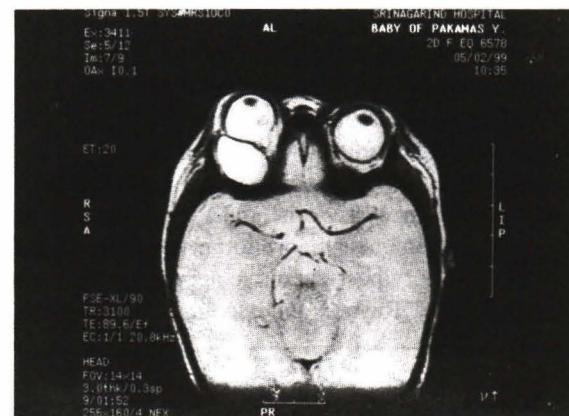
T2-weighted magnetic resonance imaging of the orbits showed a small right globe with a large cystic lesion located posteroinferiorly.
